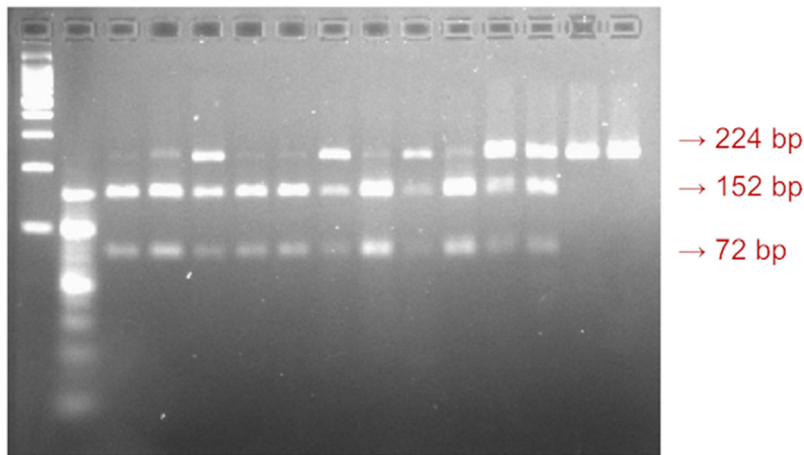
A visualization of the *FOXO3a* rs4946936 gene polymorphism. The 224bp sized band indicated TT genotype, the 152bp size band indicated CT genotype, and the 72bp sized band indicated CC genotype.
